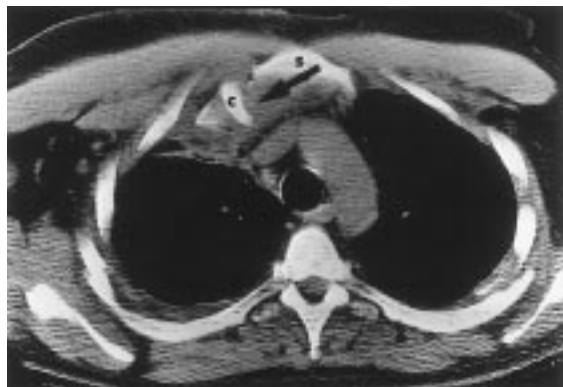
Computed tomogram of a patient who sustained a right posterior sternoclavicular joint dislocation as a result of impact of the chest against the steering wheel during a motor vehicle accident. Note the degree of displacement of the posterior medial clavicle (arrow). C = medial clavicle; S = sternum.
